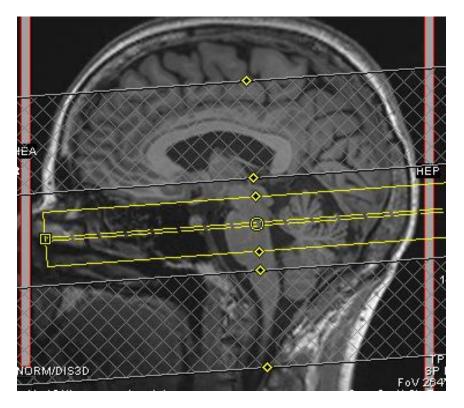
Placement of the sat bands for the LC NM-MR imaging protocol.
